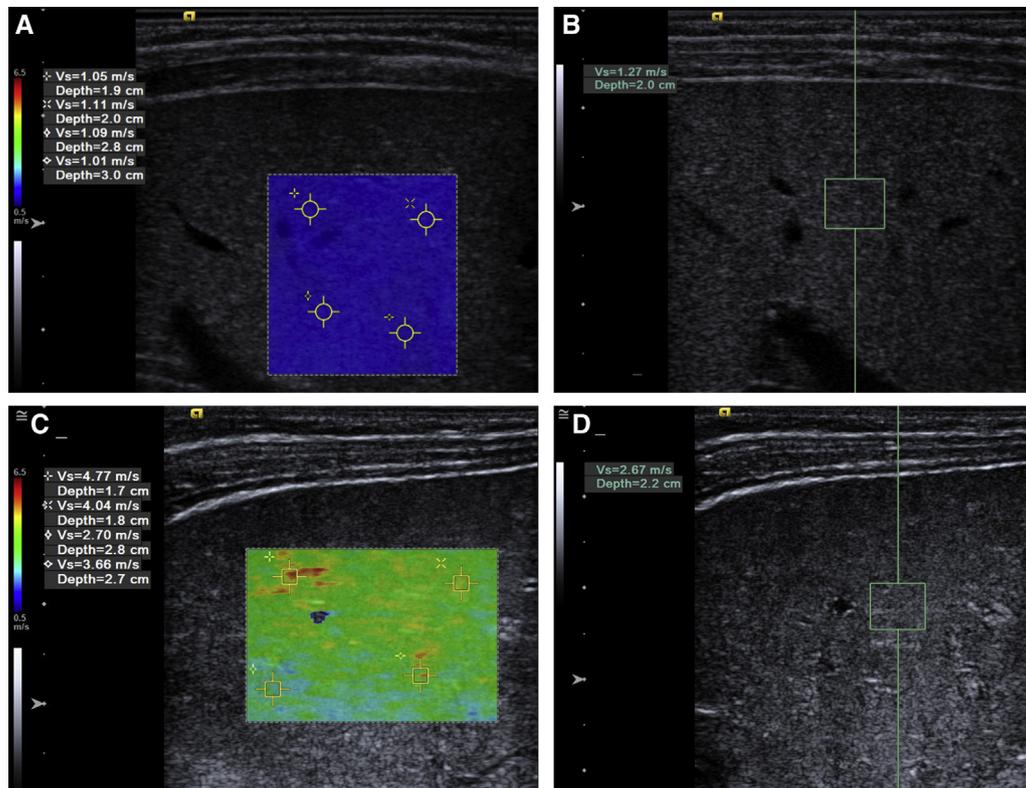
A 37-day-old boy with transient neonatal cholestasis attributed to neonatal hepatitis. A, 2D and B, point ultrasound SWE images show normal liver stiffness. Median shear wave speeds were 1.13 m/s and 1.14 m/s, respectively. C, 2D and D, point ultrasound SWE images from an 86-day-old boy with biliary atresia show marked liver stiffening. Median shear wave speeds were 3.48 m/s and 2.70 m/s, respectively.
